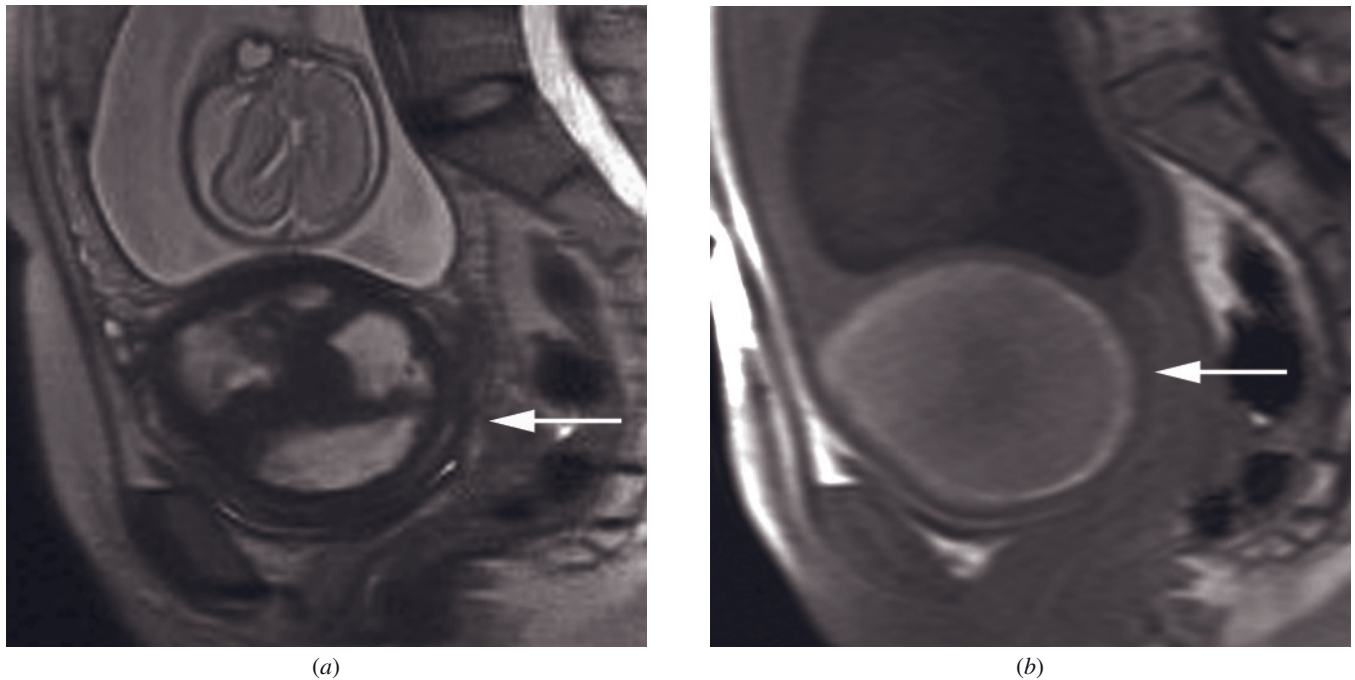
Red degeneration of leiomyoma during pregnancy. Sagittal T2-weighted SS-ETSE (a) and T1-weighted gradient echo (b) images reveal an 11-cm subserosal leiomyoma in the lower uterine segment (arrows). The leiomyoma demonstrates mixed signal on T2-weighted images and diffuse hyperintensity on T1-weighted images, consistent with red degeneration. Gravid uterus with 23-week fetus is partially visualized.
